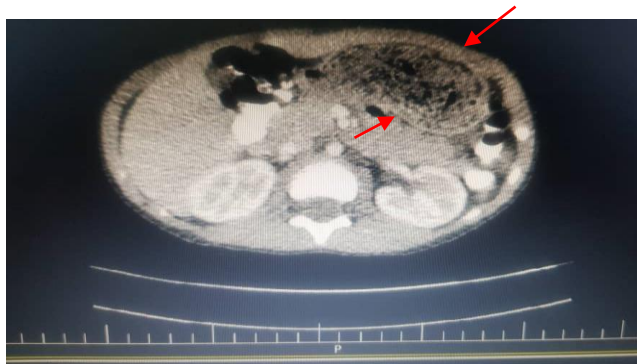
Gastric bezoar presentation in abdominal CT scan with contrast agent
